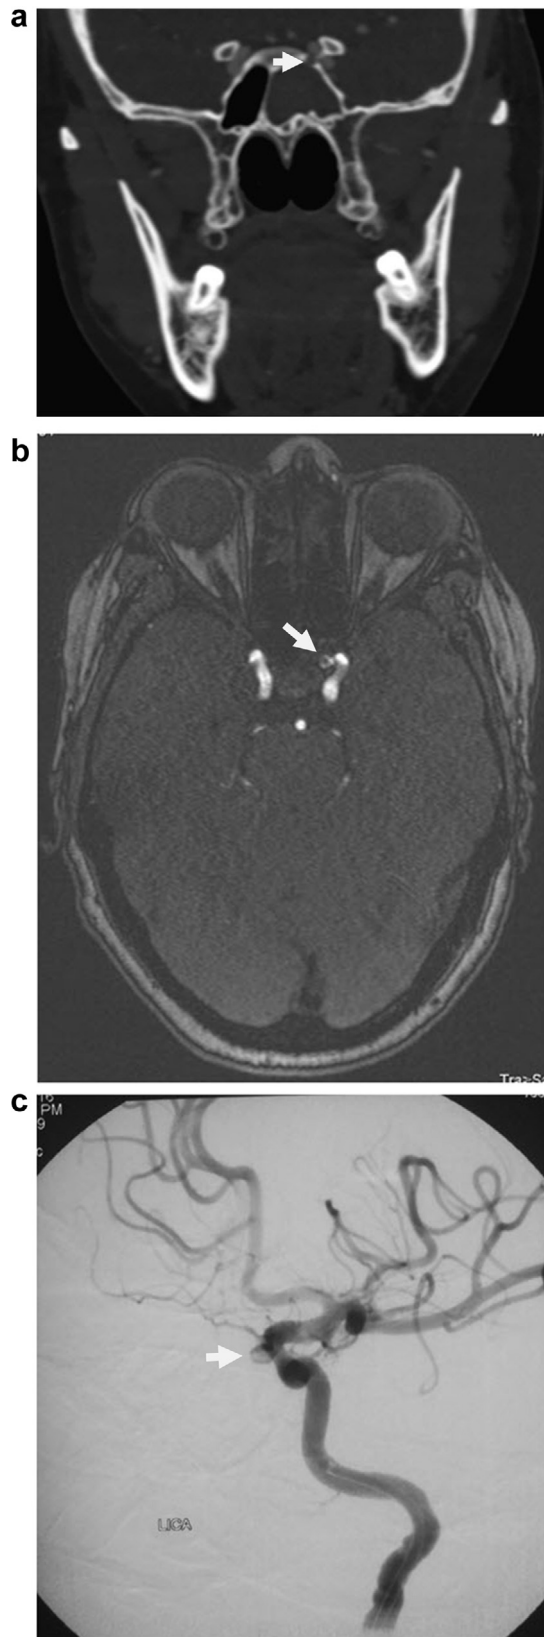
(a) CT angiography coronal section bone window shows bony defect in the left superolateral wall of the sphenoid sinus with small nibbing on the medial wall of left cavernous ICA. (b) TOF MR angiography base image showing left cavernous ICA aneurysm projecting into
